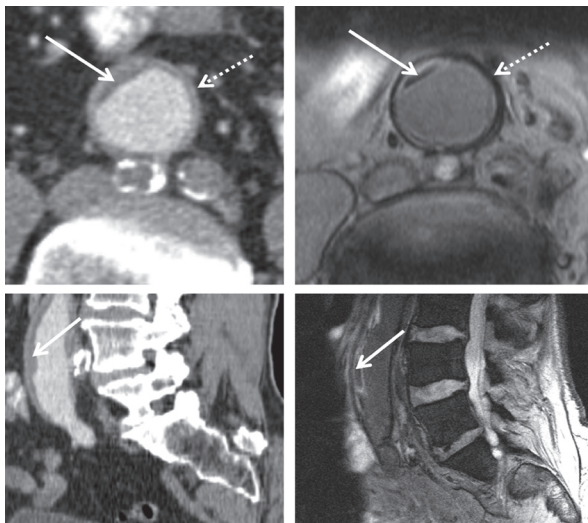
USPIO uptake in the wall and thrombus of a 3,7cm large abdominal aortic aneurysm. The dashed arrow shows diminished T2* signal intensity in the aneurysm wall (right panel), not related to the presence of calcified plaque on the corresponding CT (left panel). The full arrow shows USPIO uptake in the centre of the associated intraluminal thrombus. Note that the calcifications in the wall of the occluded venous aorto-iliac bypass graft result in diminished signal intensity on T2*-weighed MR images.
